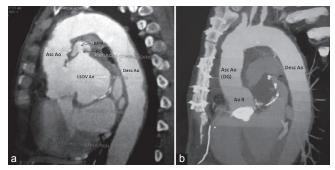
(a) Computed tomography (CT) chest in sagittal section demonstrates a large LSOV communicating with MPA (black arrow) (b) Post-surgery CT chest in sagittal section, shows ascending aorta Dacron graft and absence of any aorto-pulmonary communication. Asc: Ao ascending Aorta, Desc: Ao descending aorta, LSOV: An left sinus of Valsalva aneurysm, MPA: Main pulmonary artery, FC: Fistulous communication (white arrow), Ao R: aortic root
